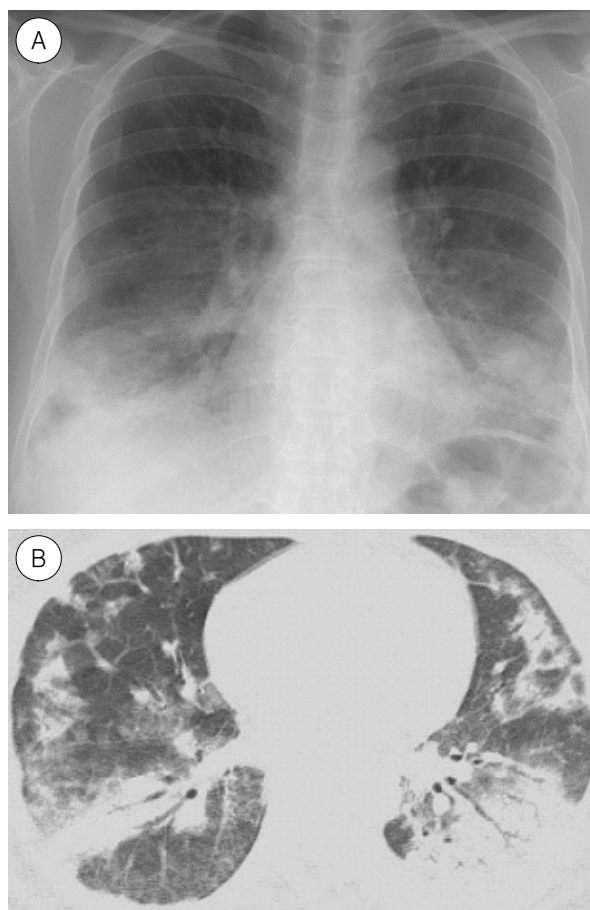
Cryptogenic organizing pneumonia in a 36-year-old man. (A) Chest radiograph shows patchy consolidation in both lower lung zones. (B) HRCT scan obtained at level of inferior pulmonary vein shows peribronchovascular and subpleural distribution of consolidation. Also note ground glass opacity and large nodules in both lungs.
